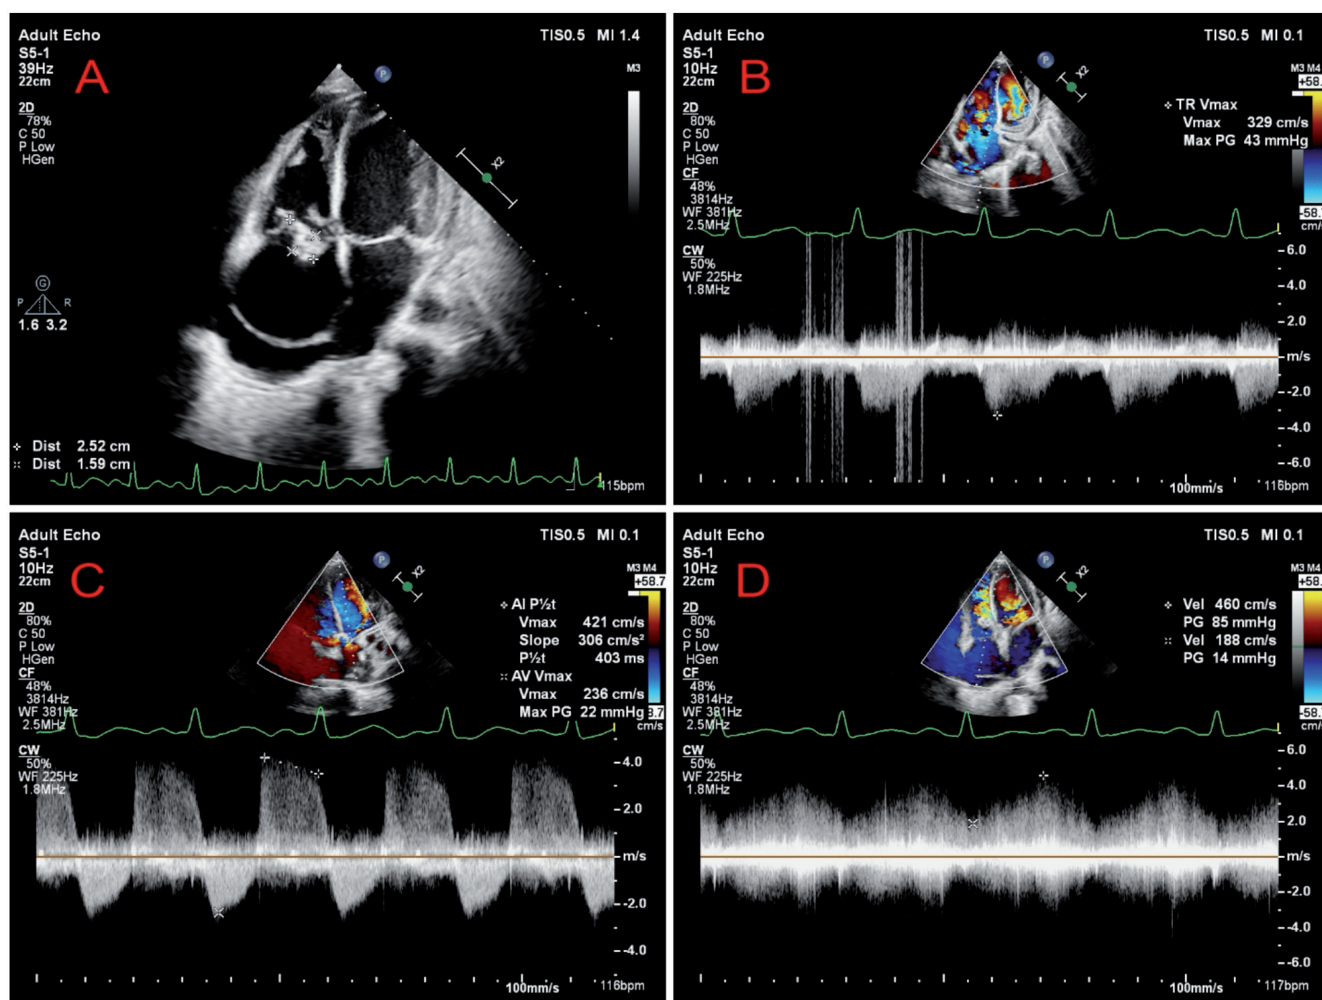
Transthoracic echocardiography images. A) Apical four chamber (A4C) view demonstrating mass of size 25×16 mm around tricuspid valve with borderline enlargement of right atrium and right ventricle, and mild pericardial effusion; B) continuous wave (CW) doppler across tricuspid valve demonstrating moderate tricuspid regurgitation with maximum pressure gradient of 43 mmHg; C) CW doppler across aortic valve demonstrating mild eccentric aortic regurgitation with pressure half time (PHT) of 403 ms; D) CW doppler across tricuspid valve demonstrating continuous flow with a maximum and minimum gradient of 85 mmHg and 14 mmHg respectively.
